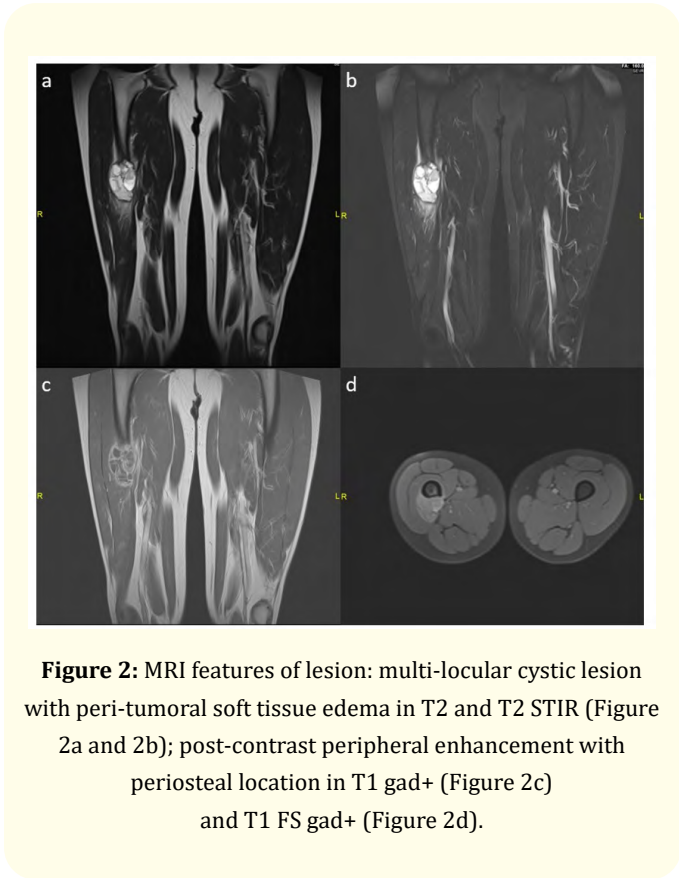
MRI features of lesion: multi-locular cystic lesion with peri-tumoral soft tissue edema in T2 and T2 STIR (Figure 2a and 2b); post-contrast peripheral enhancement with periosteal location in T1 gad+ (Figure 2c) and T1 FS gad+ (Figure 2d).
